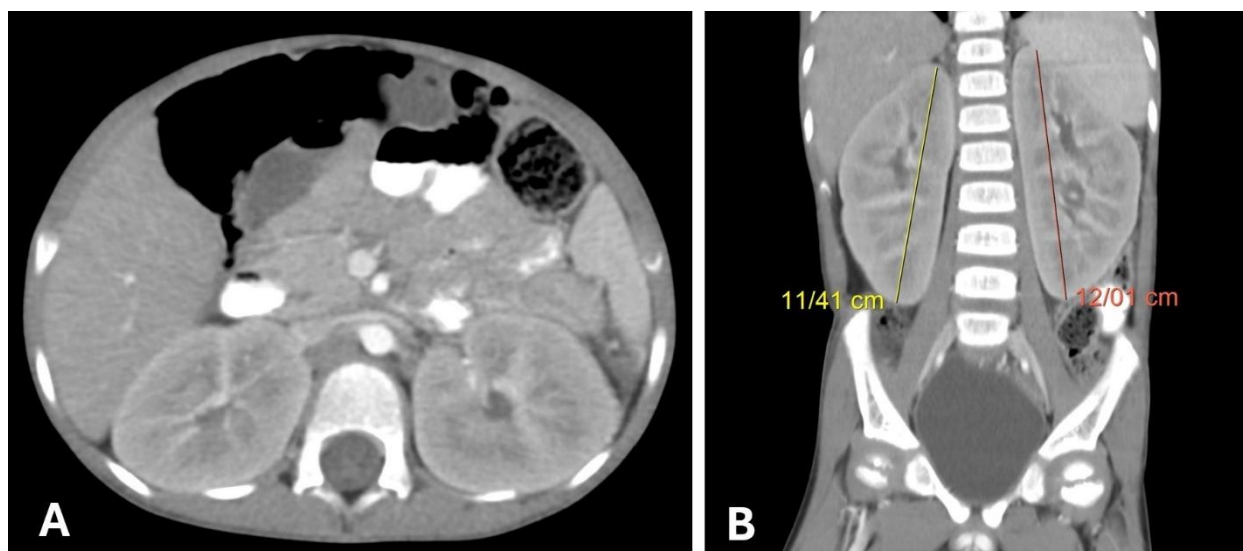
CT scan of abdominal organs in transverse (A) and coronal (B) views. The kidneys are larger than normal and are free of stones or hydronephrosis.
